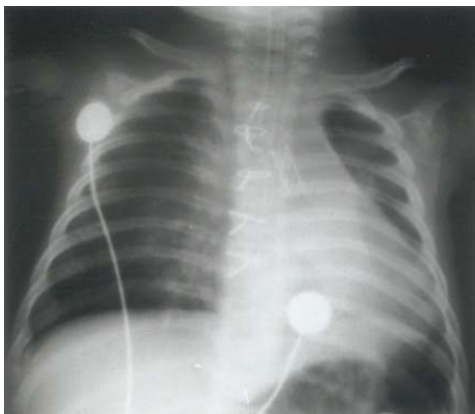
Post-procedure chest radiograph showing that the lung fields have normal radiographic appearance; the stent is located within the left main bronchus.
